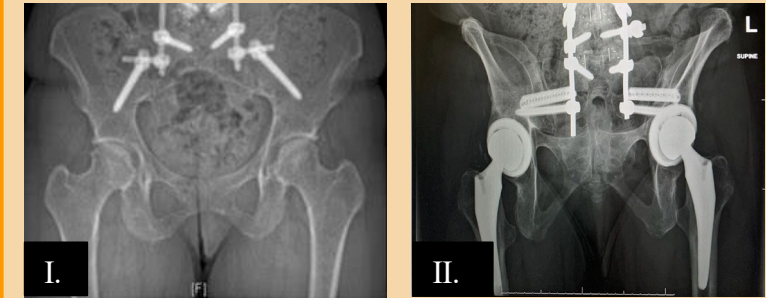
Anterior radiographic images of I. patient with ASD treated with S2AI screws and II. Patient with ASD treated with S2AI + TTI⁴.
